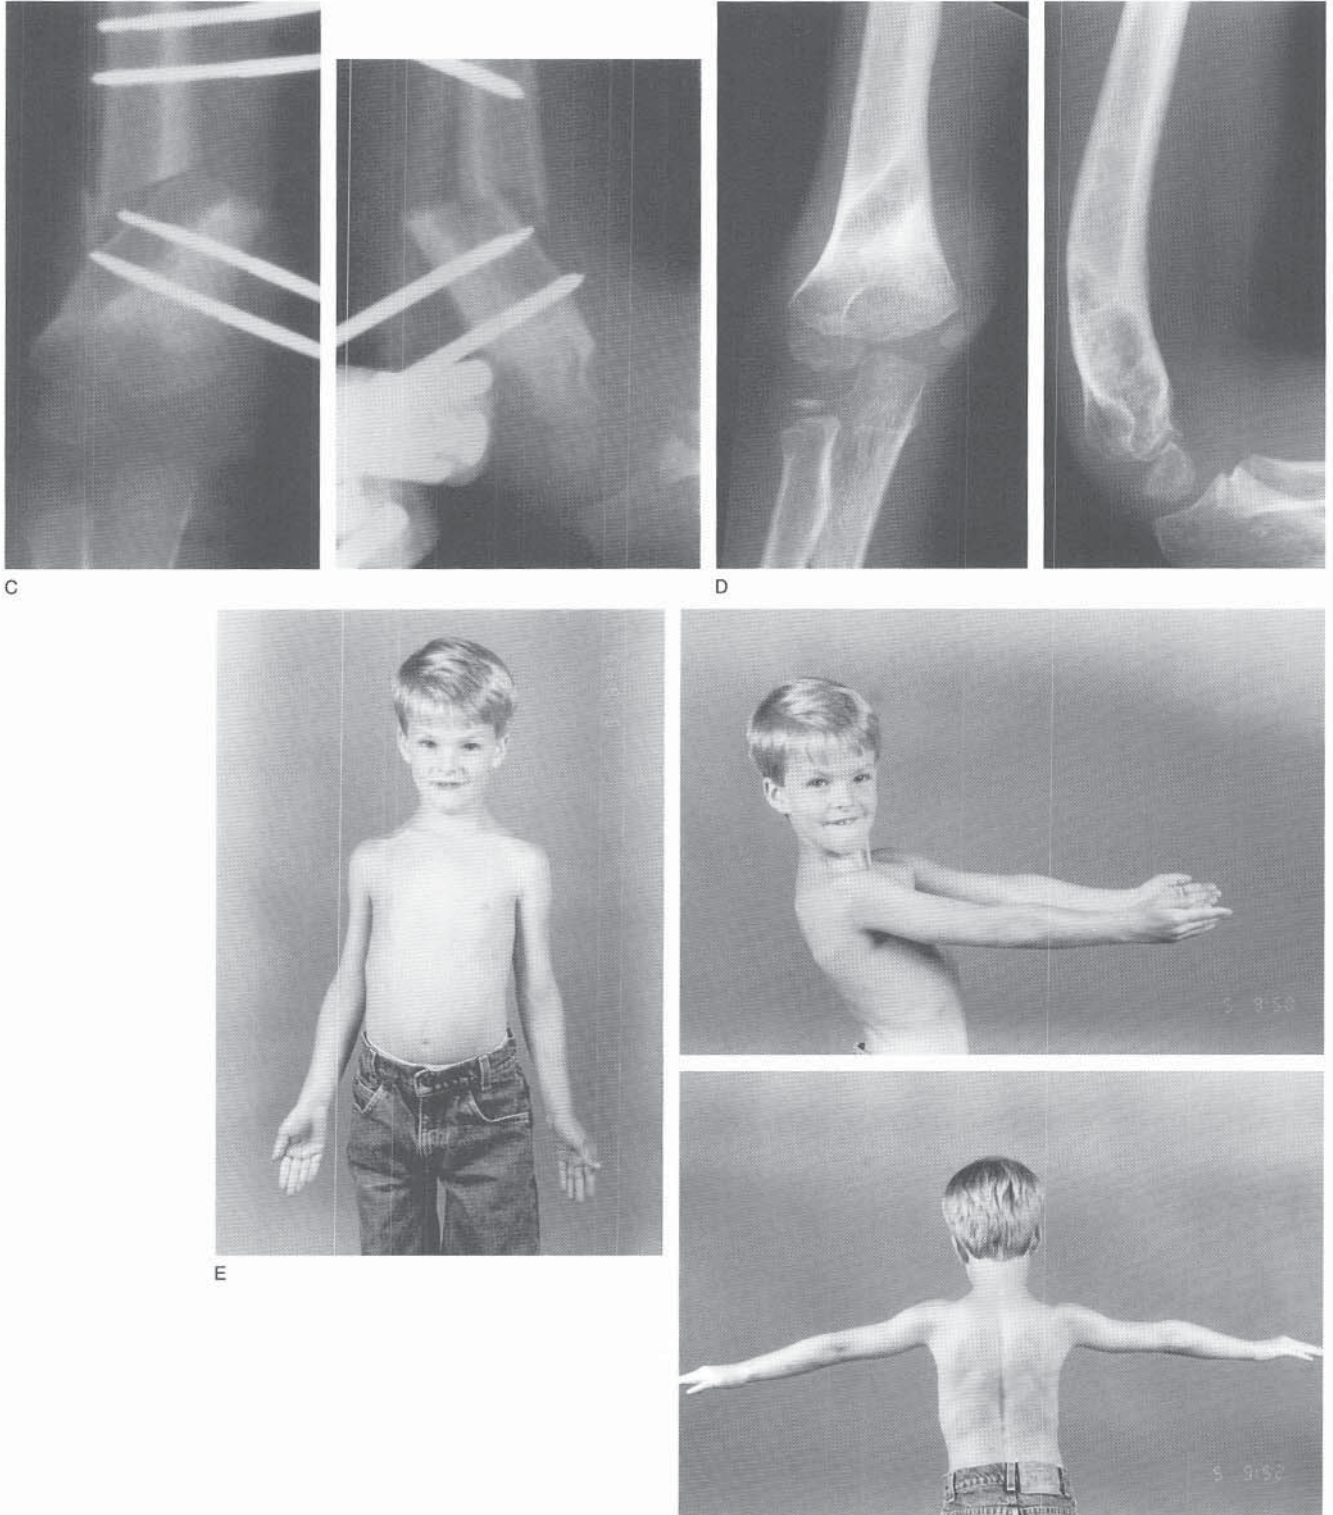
Continued.* C, Immediate postoperative films showing the opening wedge osteotomy without a bone graft. The external fixator allows sagittal plane correction. D, AP and lateral radiographs obtained 1 year postoperatively. Significant remodeling has occurred. E, Clinical appearance 1 year postoperatively.
